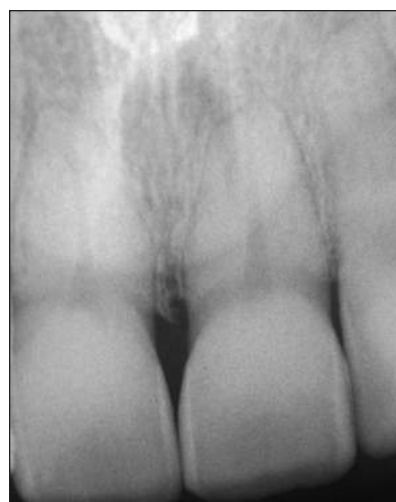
A radiograph taken 21 years after Figure 10A shows no evidence of resorption.
